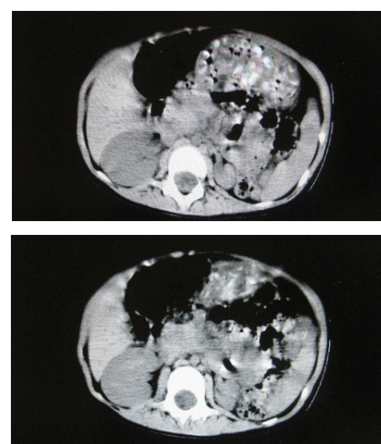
Abdominal CT shows left kidney dysplasia and significant shrink of its size.
